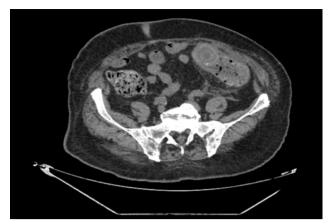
Transverse plane abdominal computed tomography (CT) scan showing a calcified gallstone within the sigmoid colon.
